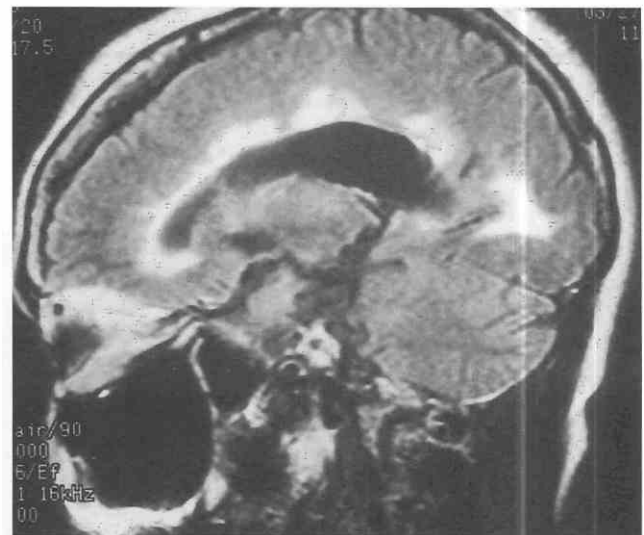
Multiple sclerosis (MS). Fluid-attenuated inversion recovery (FLAIR) parasagittal MR image depicts the extensive demyelinated plaques of progressive MS.
